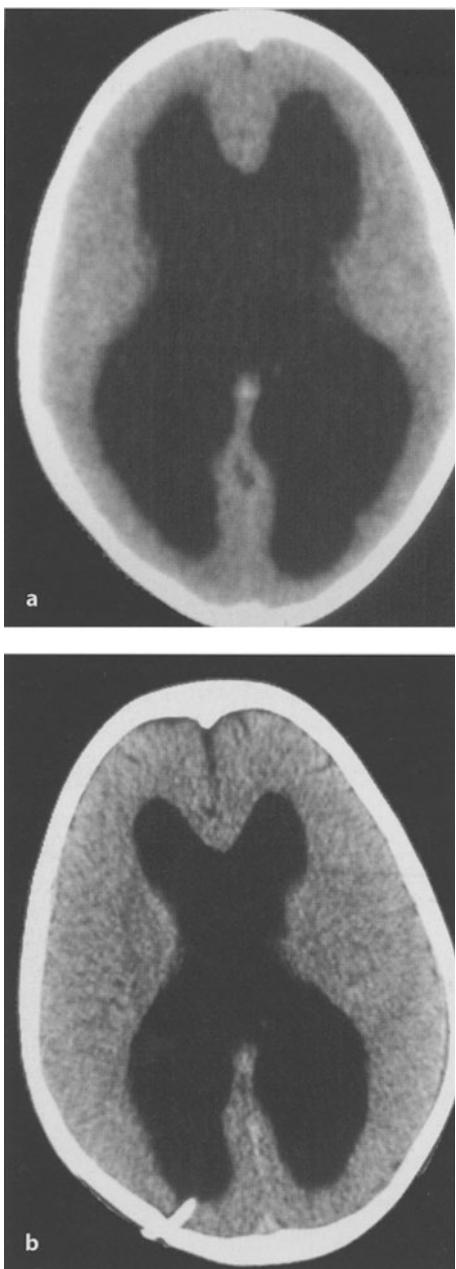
A 7-year-old girl affected by myelomeningocele and hydrocephalus. Shunted at birth, her shunt was removed at the age of 2 months because of shunt infection and never re-implanted because the hydrocephalus was considered to be "arrested". She was admitted at the age of 7 years with macrocrania, papilloedema and mildly delayed psychomotor development. MRI showed hydrocephalus (a). Significant radiological and clinical improvement was observed after ventriculoperitoneal shunt (b)
